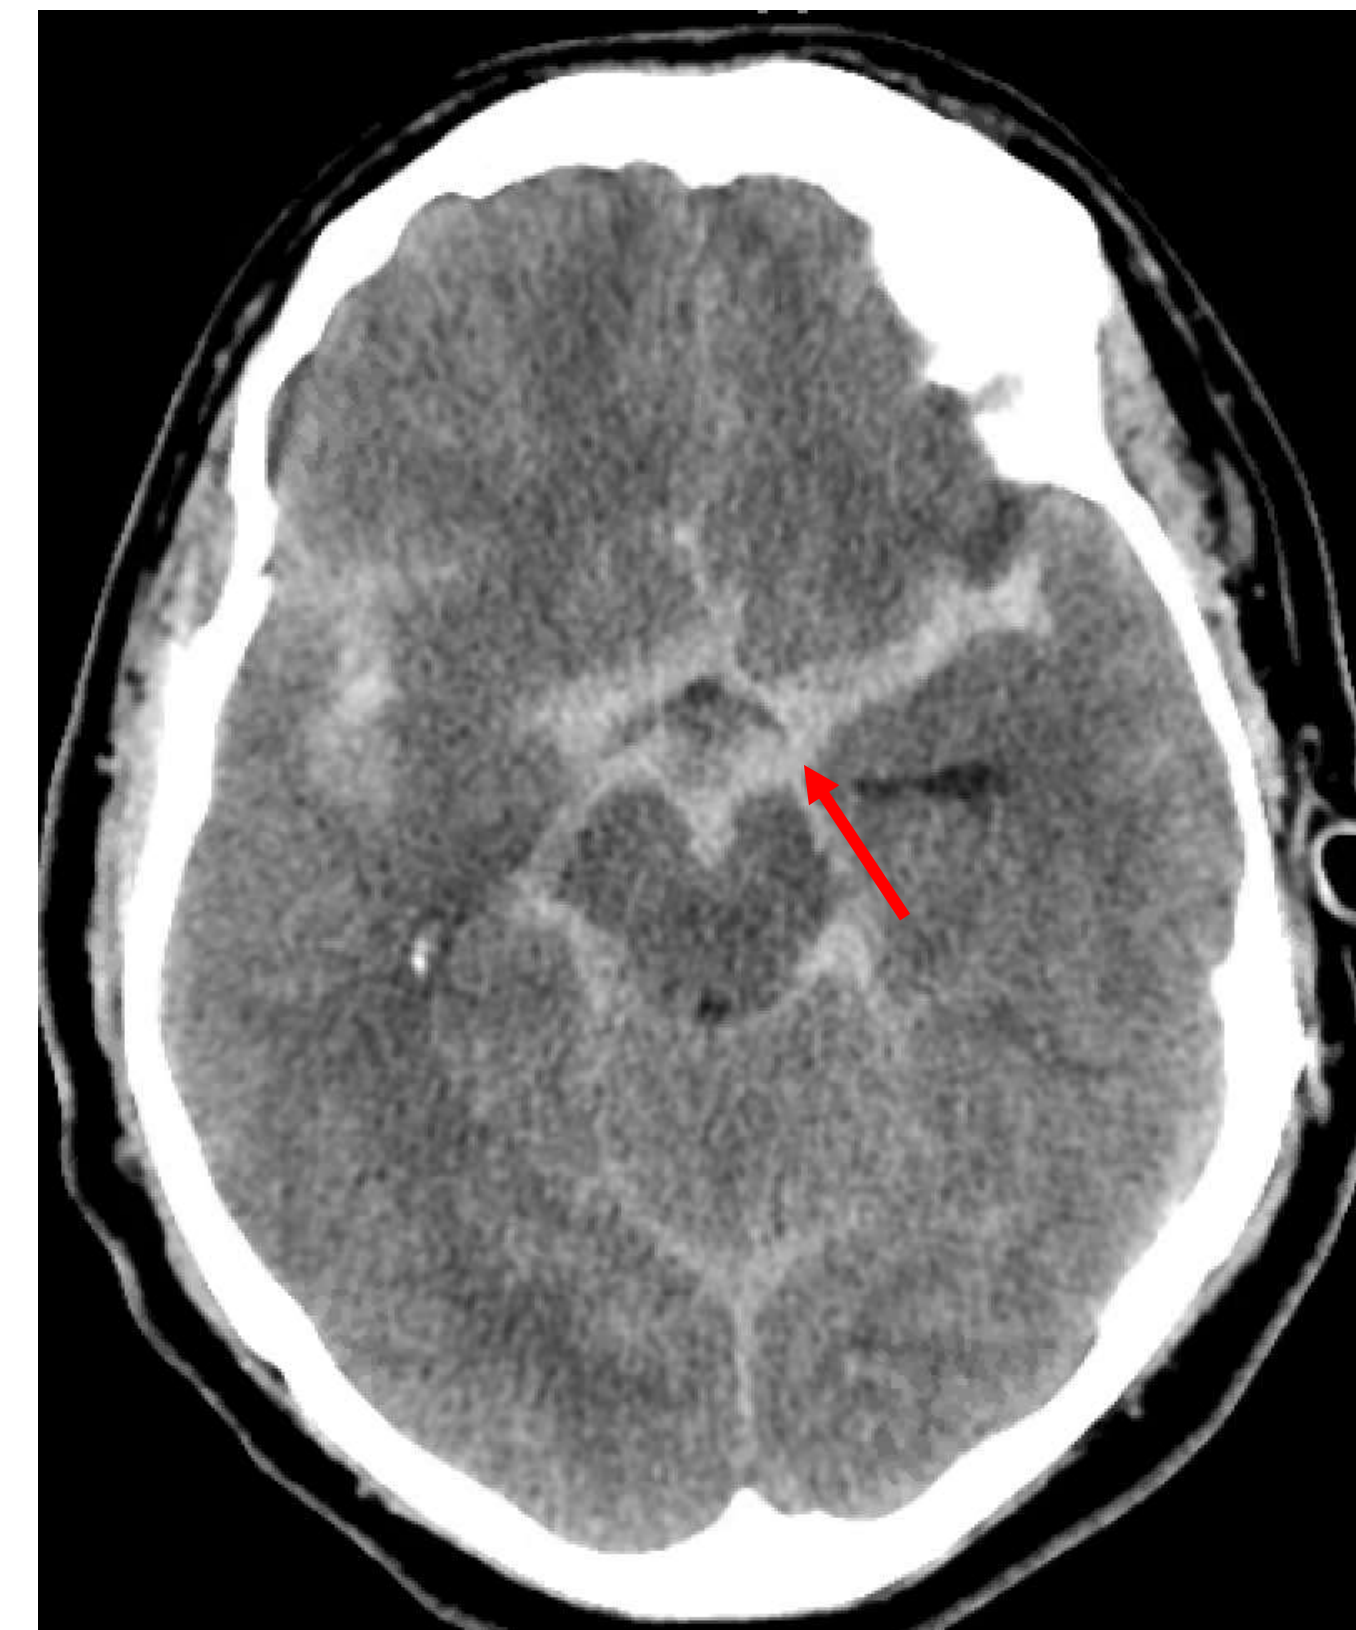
CT head without contrast on presentation revealing subarachnoid hemorrhage involving the perimesencephalic cisterns (A), intraventricular hemorrhage, and hydrocephalus.
